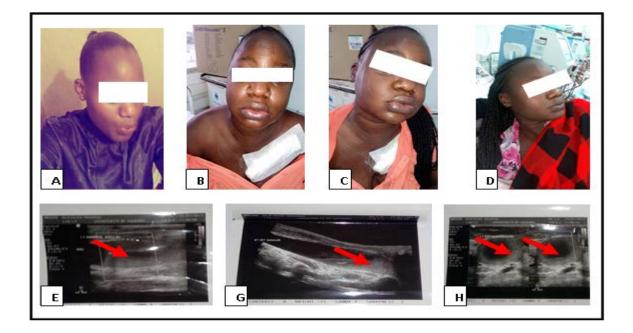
A- - M.M face before thrombosis, B-C M.M face at presentation. D- M.M face after 3 weeks of treatment, E-H: Doppler ultrasound depicting the thrombosis (red arrows)
